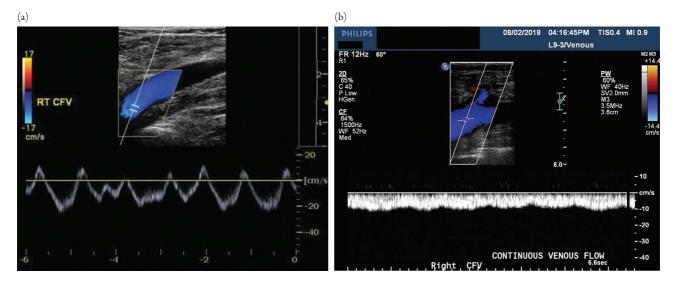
(a) Spectral Doppler tracing of the right common femoral vein in a patient with normal phasic variation. Adapted from Figure 1a of Lin EP, Bhatt S, Rubens D, Dogra VS. The importance of monophasic Doppler waveforms in the common femoral vein: a retrospective study. *J Ultrasound Med.* 2007;26(7):885–891. (b) Spectral Doppler tracing showing a monophasic waveform in the common femoral vein. Adapted from Figure 1b of Lin EP, Bhatt S, Rubens D, Dogra VS. The importance of monophasic Doppler waveforms in the common femoral vein: a retrospective study. *J Ultrasound Med.* 2007;26(7):885–891.
